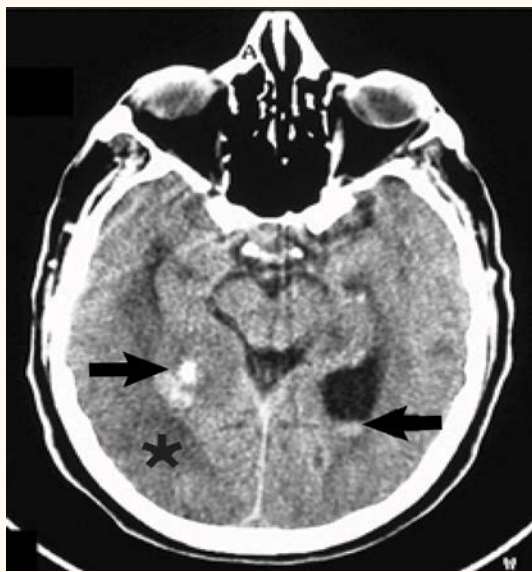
Axial non-enhanced brain computed tomography scan showing the haemorrhagic tumoral mass occupying the right occipital horn (black arrow, left) with surrounding vasogenic oedema (black star). A blood level is seen in the left one (black arrow, right).
